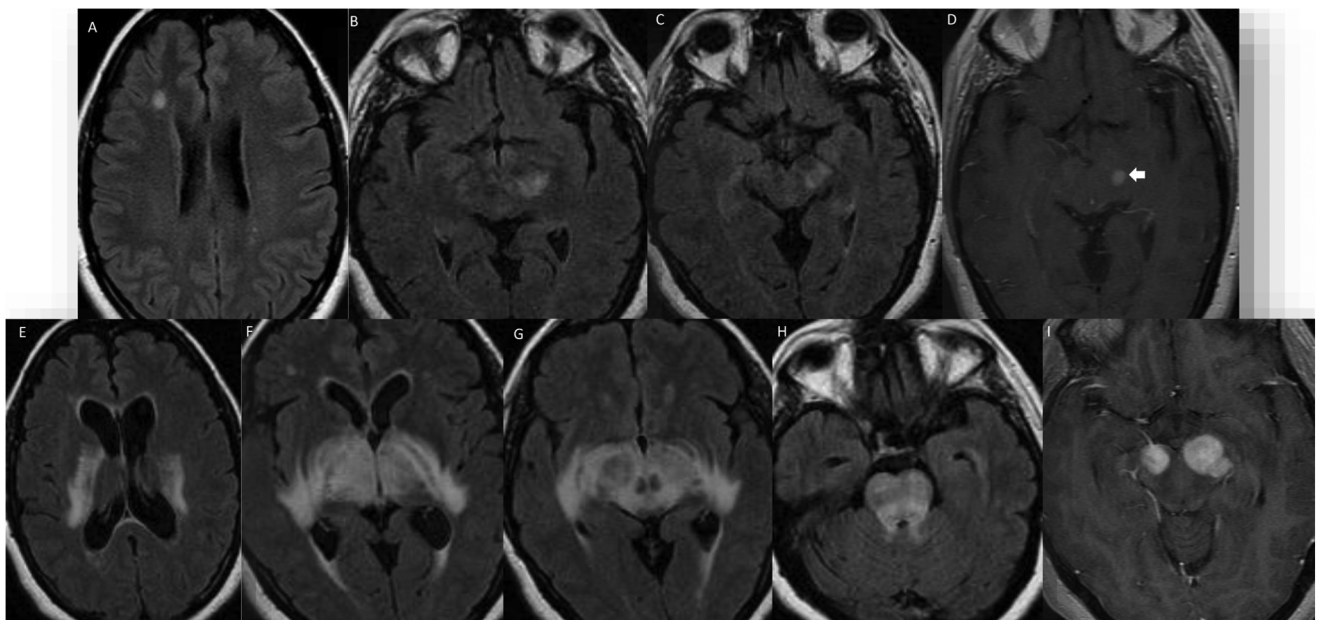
Forty-one-year-old woman with a neurological history of over a year with right faciobrachial paresis. MRI images in the top row (A–D) show the first MRI with hyperintense lesions in FLAIR sequences, non-specific, with extension through the left cerebral peduncle to the midbrain where a small millimetre-sized nodular uptake focus is identified (arrow). Follow-up MRI one year later, bottom images (E–I), shows a clear worsening consisting of signal hyperintensity in T2-weighted and FLAIR sequences affecting both internal capsules and corona radiata and extending through the posterior arm of the internal capsules and through both cerebral peduncles to the entire midbrain. The white matter of both temporal lobes in contact with the ventricular horn is also affected, as well as both optic tracts. In contrast-enhanced sequences there is intense solid uptake of nodular morphology in both cerebral peduncles. Brain biopsy confirmed DLBCL.
